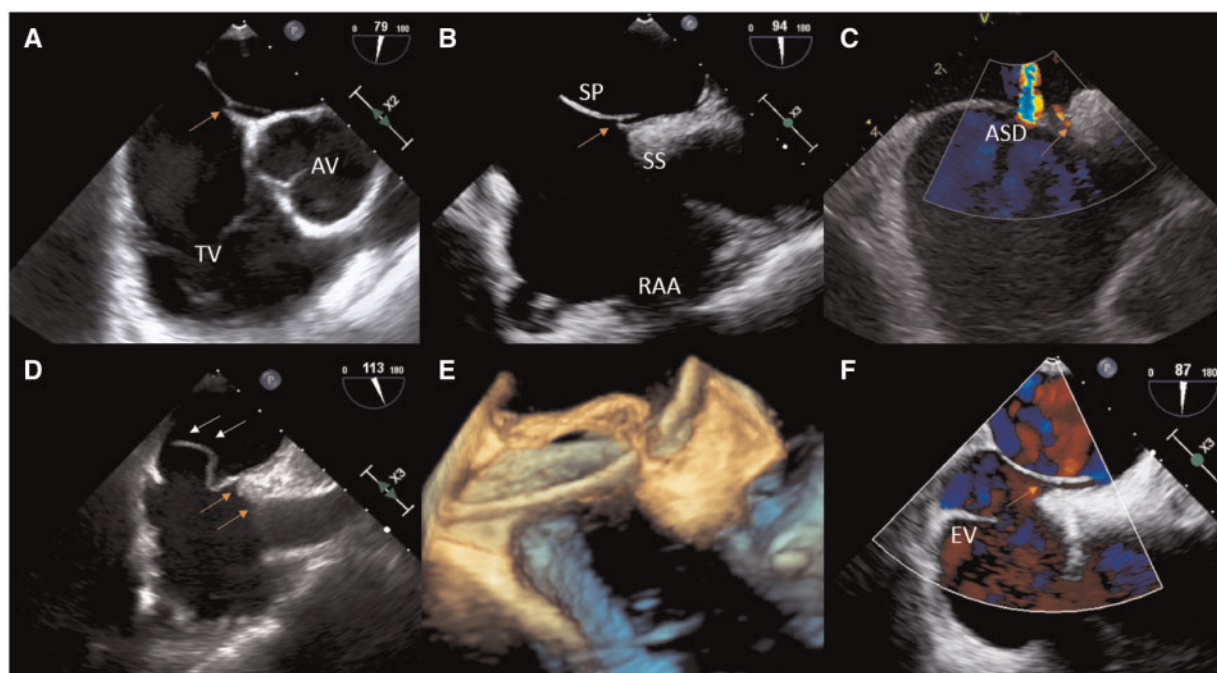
Various phenotypes of patent foramen ovale on echocardiography. (A) a simple patent foramen ovale with short tunnel. (B) Patent foramen ovale with thickened septum secundum. (C) Patent foramen ovale with small septum secundum atrial septal defect. (D, E) Patent foramen ovale with atrial septal aneurysm. (F) Long tunnel patent foramen ovale with a prominent Eustachian valve. ASD, atrial septal defect; AV, aortic valve; EV, Eustachian valve; RAA, right atrial appendage; SP, septum primum; SS, septum secundum; TV, tricuspid valve.
